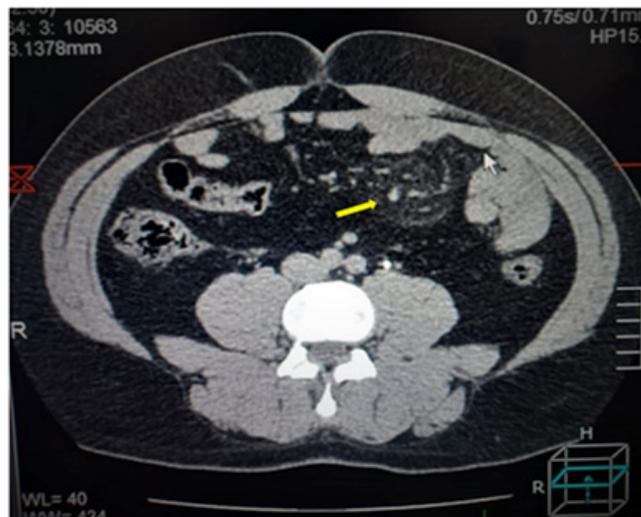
Abdominal CT scan with contrast injection in axial section showing mesenteric fat overdensity with the presence of a hypodense fat halo around the mesenteric vessels (fat ring sign).
